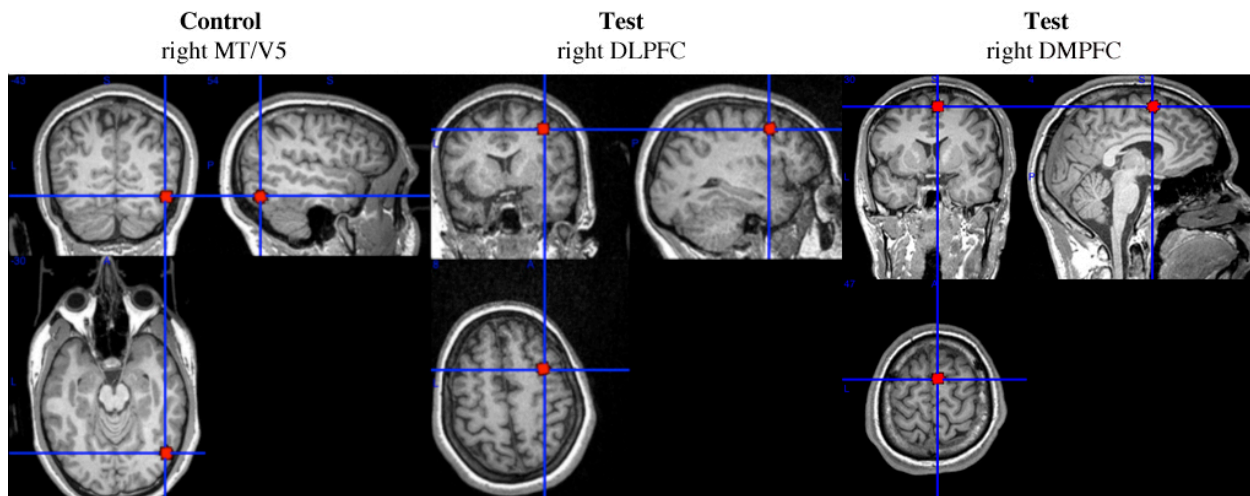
Stimulation sites. Control site: area MT/V5 ($x = 48\text{mm}$, $y = -74\text{mm}$, $z = 0\text{mm}$). Test sites: DLPFC ($x = 40\text{mm}$, $y = 24\text{mm}$, $z = 38\text{mm}$) and DMPFC ($x = 8\text{mm}$, $y = 24\text{mm}$, $z = 54\text{mm}$). ROI's are displayed on a single-subject high-resolution T1-weighted images in neurological orientation.
